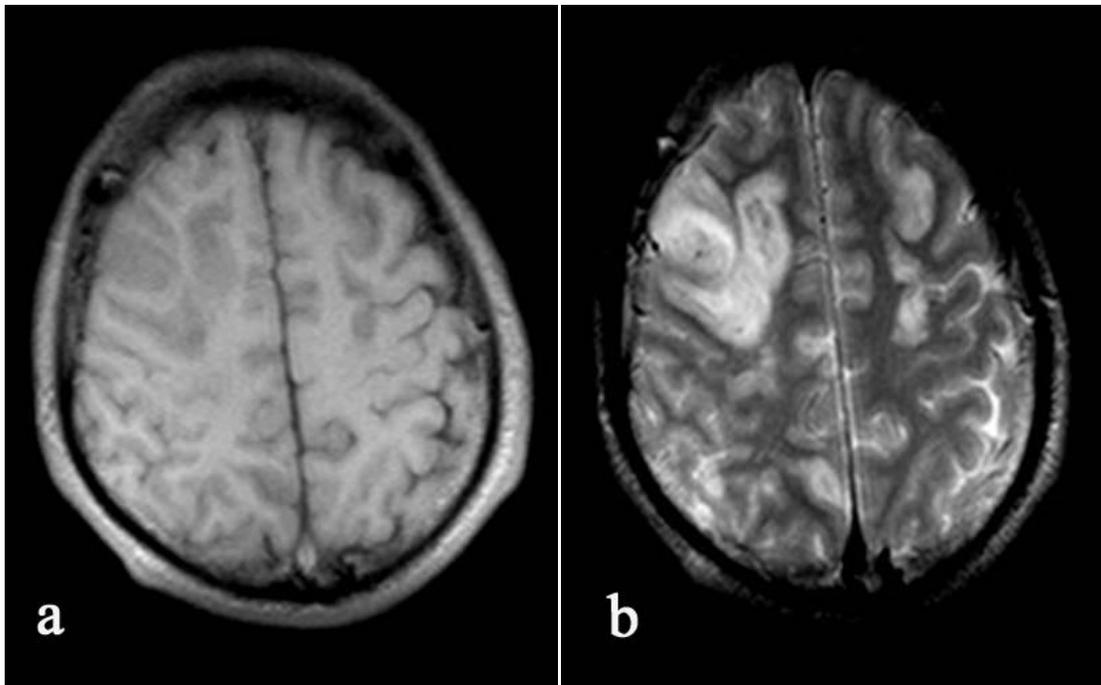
Axial cranial MRI. T1, T2 weighted images indicate abnormal long-T1, long-T2 signals in the right frontal lobe. a, T1-weighted images, b; T2-weighted images.
